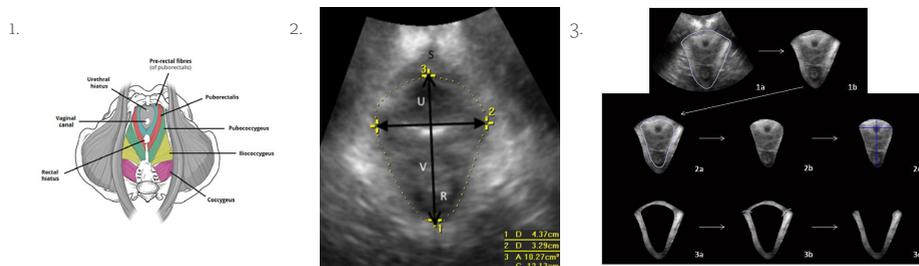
1. Anatomy of the pelvic floor. 2. Three-dimensional transperineal ultrasound examination in the axial plane with manual measurements of levator hiatus dimensions. Arrow represents anteroposterior (AP) diameter of levator hiatus (1); filled arrow represents transverse diameter of levator hiatus (2); dotted line represents area of levator hiatus (3); S=symphysis pubis; U=urethra; V=vagina; R=rectum. 3. Delineation method of the puborectalis muscle to obtain the area and echogenicity of the puborectalis muscle and the hiatal dimensions.¹⁰
